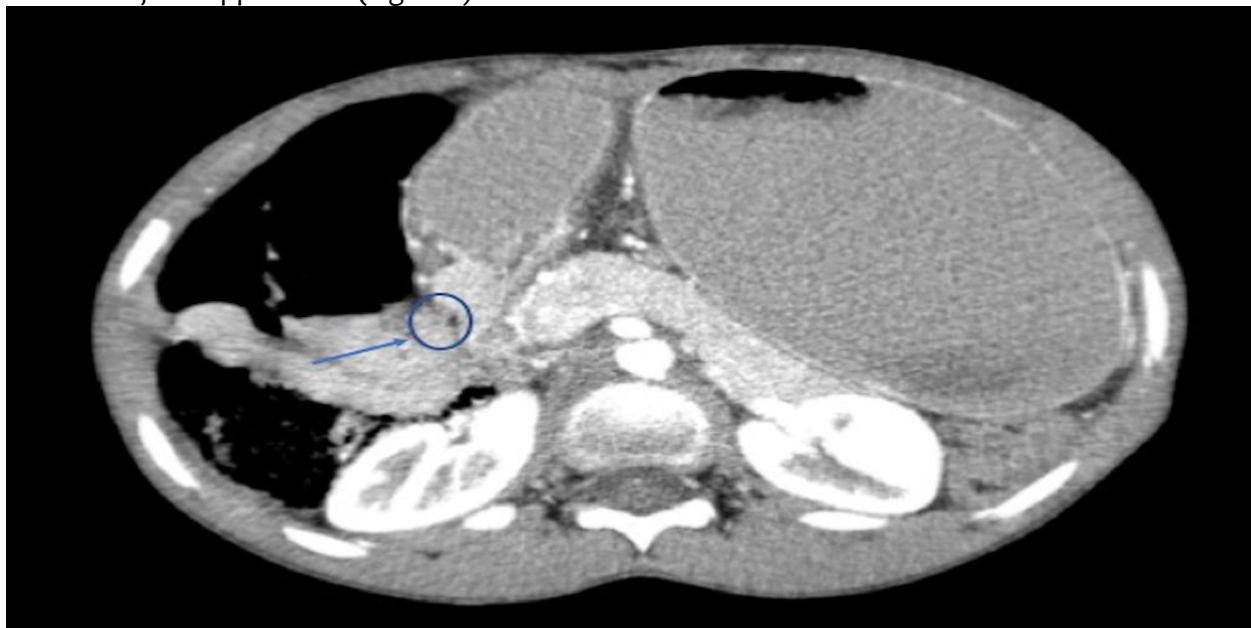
Abdominal computed tomography shows an abrupt narrowing of the duodenal bulb and a massively dilated stomach
